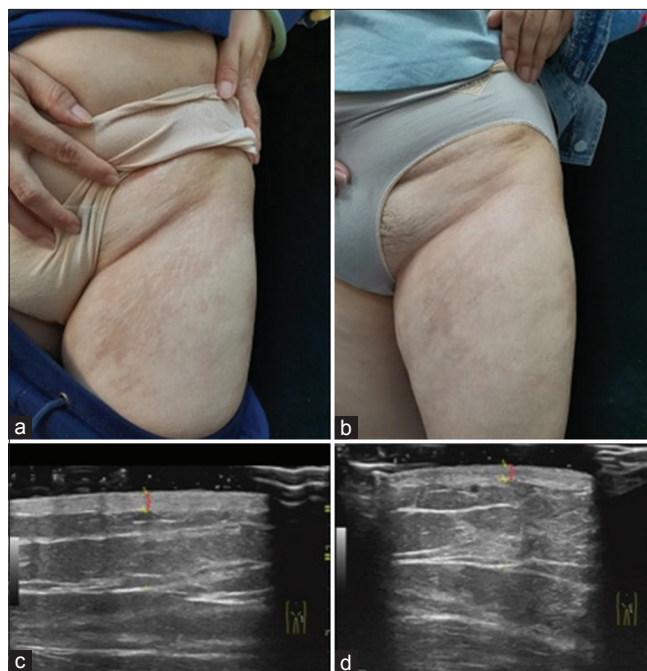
(a and b) Localized morphea lesion in the groin with clinical improvement of the lesion during the six-month treatment period. (c and d) Changes in dermal thickness, as indicated by red arrow, on 15-MHz ultrasound before and after the treatment
